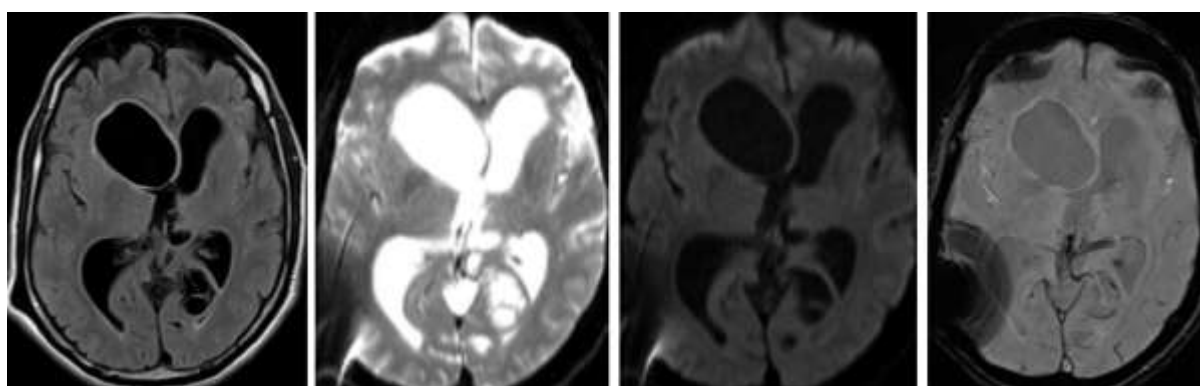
Axial FLAIR, diffusion weighted, ADC and gradient images (in sequence) show that the lesions are following CSF signal intensity with no perilesional edema or adjacent brain parenchymal gliosis, no diffusion restriction or blooming.
